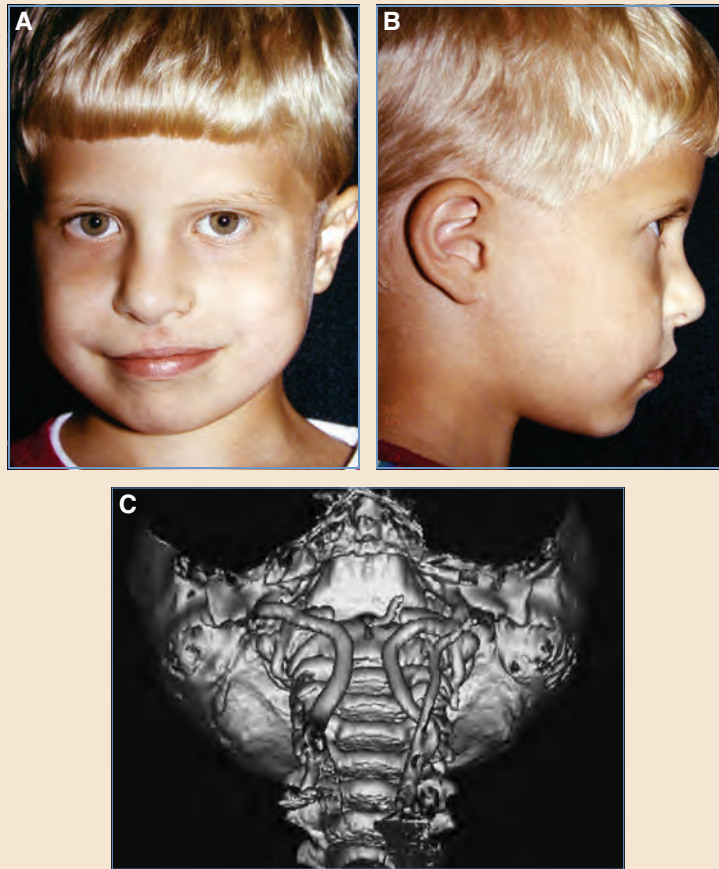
22q deletion syndrome. A and B, This 7-year-old boy had been receiving speech therapy since he was 3 years of age. He has a short, immobile soft palate with a submucous cleft. He exhibits a broad nasal dorsum with narrow alar bases, flattened zygomatic arches, platybasia, and vertical maxillary excess. At the time of his planned pharyngoplasty, it was noted that he had medially displaced carotid arteries. C, CT angiography of the carotids of another patient with the same syndrome.
